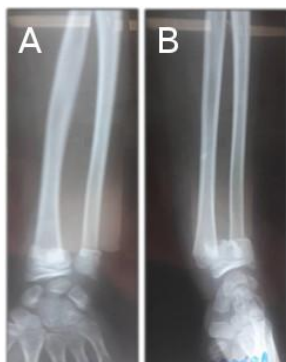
The preoperative anteroposterior (A) and lateral X-rays of a completely dislocated fracture of the distal radius in a child (B)
